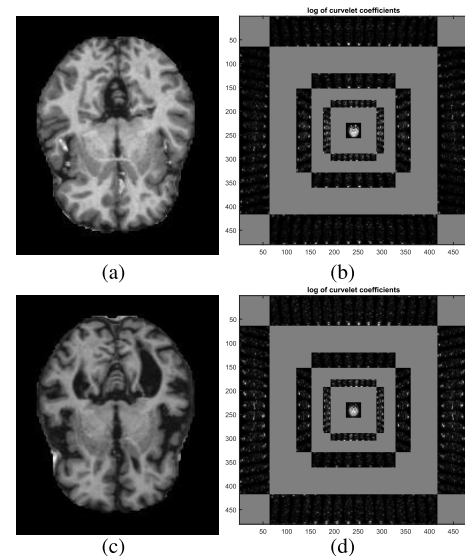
Example of MRI images and their FCT: (a) ND brain, (b) decomposed curvelet sub-bands of (a), (c) VMD brain, and (d) decomposed curvelet sub-bands of (c).
